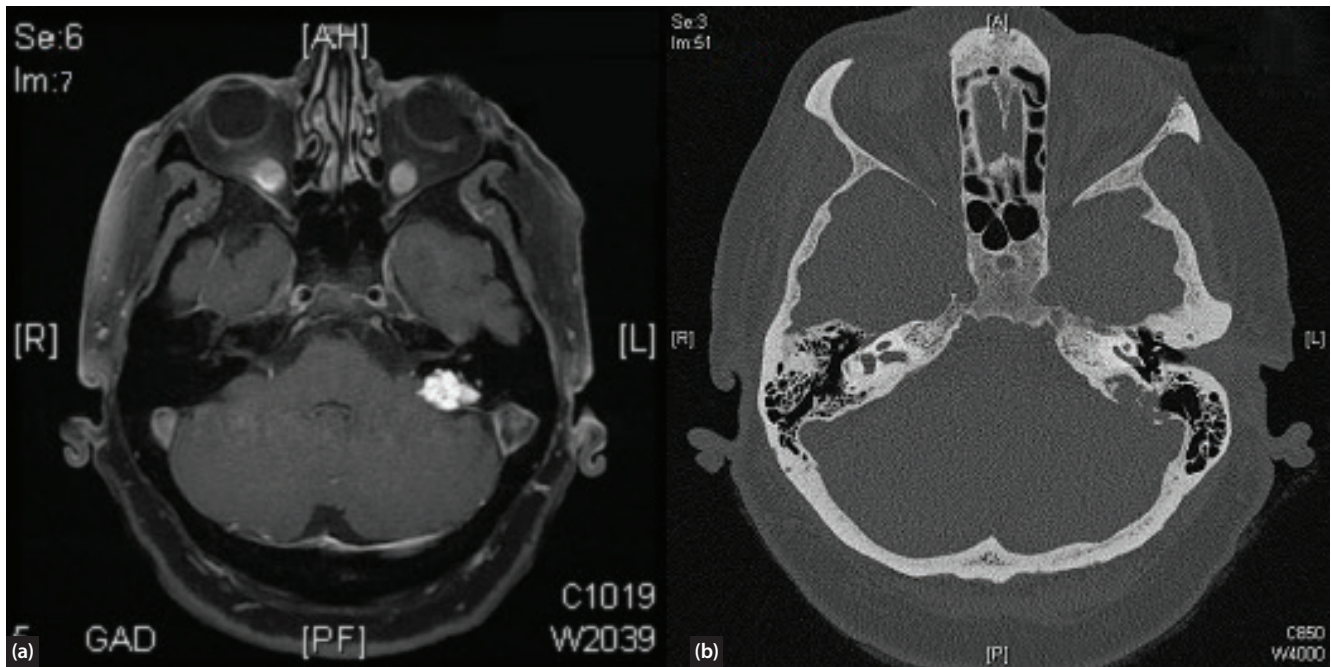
MRI scans showing a left endolymphatic sac adenocarcinoma. (a) Axial T1-weighted MRI scan with gadolinium enhancement. (b) CT scan.
